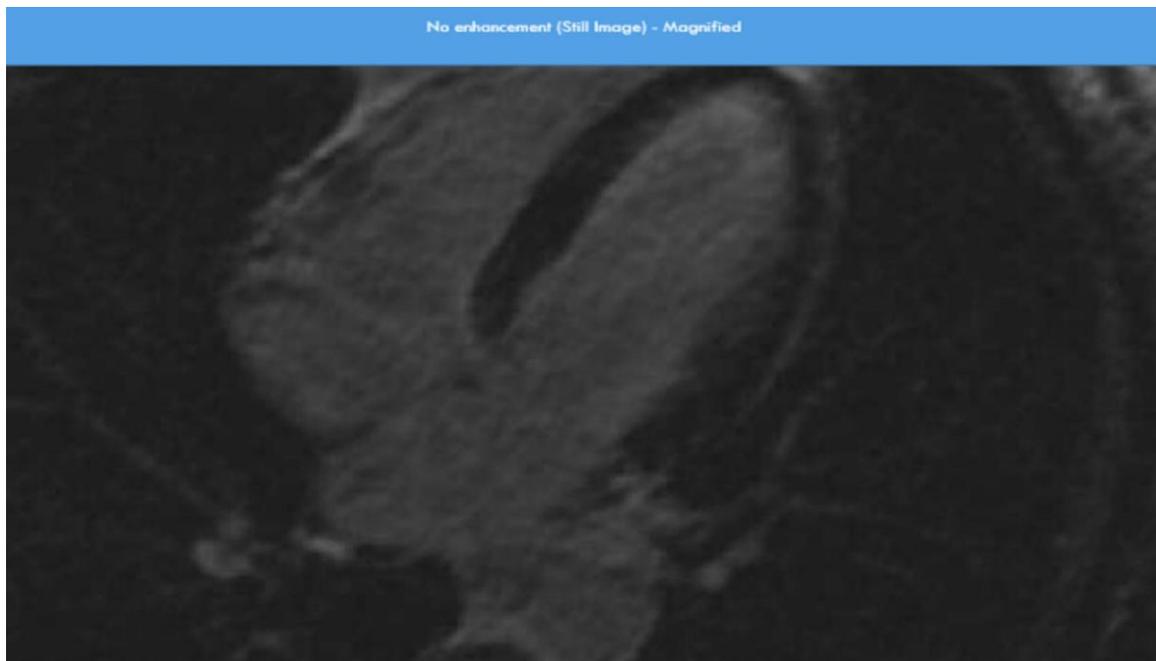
MRI showed negative finding for delayed hyper enhancement with contrast
